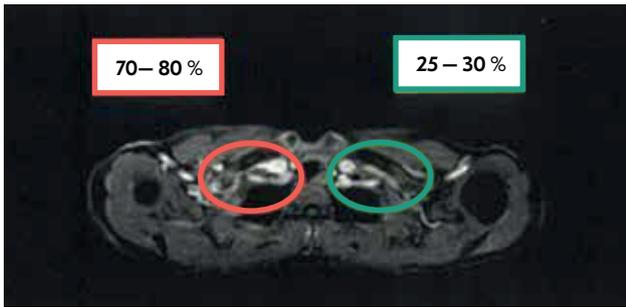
MRI of the patient with arms in forced abduction, axial slice. A stenosis of 70 – 80 % of the right subclavical vein is calculated (marked in red), while the left subclavical vein presents a light reduction of only 25 – 30 % (in green).
